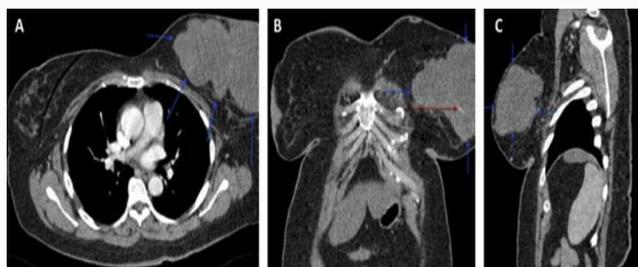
Images of a CT scan of the chest after IV contrast in the arterial phase and in the soft tissue window without significant improvement after administration of IV contrast. A). Axial view A large mass of lobulated soft tissue density in the left breast corresponding to the mammographic mass seen above (blue arrows) is partially seen in the field of vision. The displayed portion measures 9 cm (AP) × 12 cm (TS). No enlarged axillary or internal mammary lymph nodes are observed. YES). Coronal Image A large mass of lobulated soft tissue density in the left breast corresponding to the mammographic mass seen above (blue arrows) is partially seen in the field of vision. Few central calcifications were observed (red arrow). The displayed portion measures 12 cm (TS) × 12 cm (Skull-Flow, CC). C) Parasagittal image. A large mass of lobulated soft tissue density in the left breast corresponding to the mammographic mass seen above (blue arrows) is partially seen in the field of vision. The portion displayed is 9 cm (AP) × 12 cm (CC).
